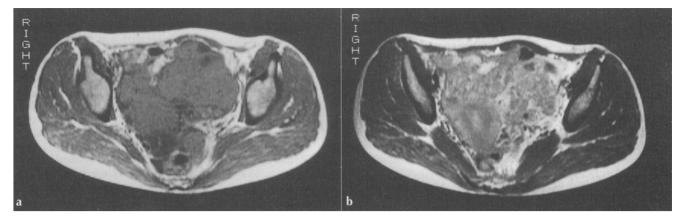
Axial magnetic resonance imaging of patient 3. (A) Unenhanced T1-weighted (SE 500/20) image shows an almost solid mass with a low signal intensity. (B) Gadolinium- enhanced T1-weighted (SE 500/20) image clearly showing irregular high-intensity signals.
